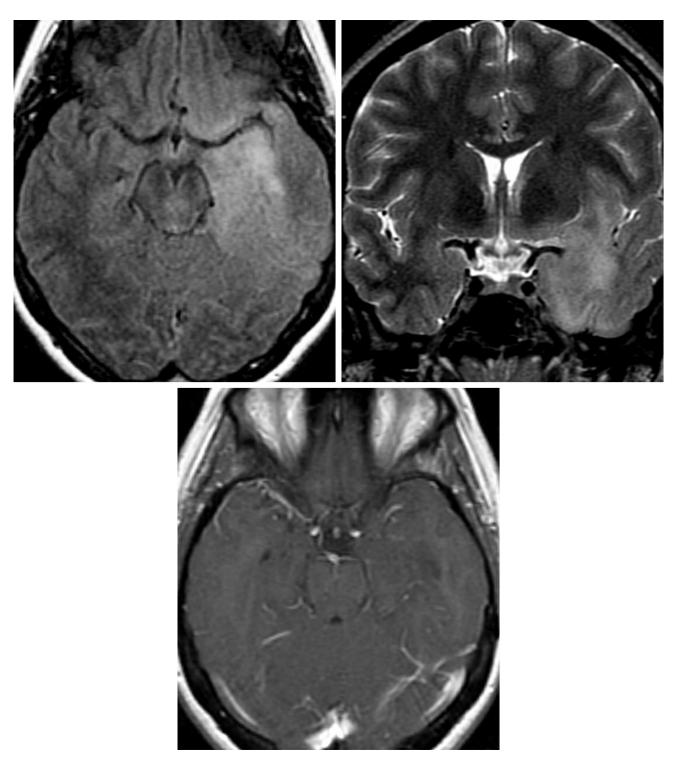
Axial FLAIR (top left) and coronal STIR (top right) images demonstrate a poorly defined infiltrative, hyperintense lesion involving the left temporal lobe, left insula, and inferior left frontal lobe. (Bottom) T1WI after contrast administration shows no contrast enhancement of this low-grade astrocytoma.
